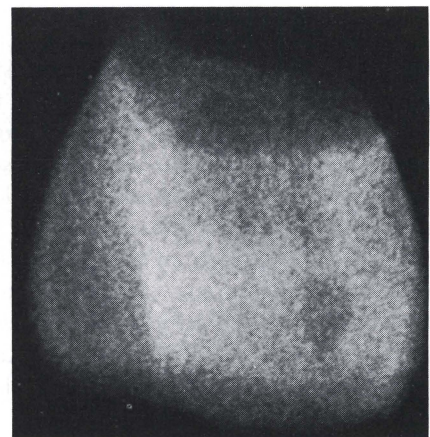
Radiograph taken in a buccolingual direction. Again, no evidence of a pulpal horn in the talon cusp.
